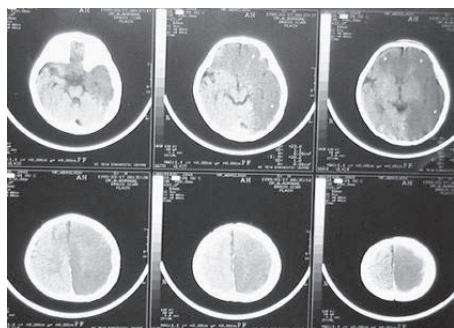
Axial CT shows extensive hypodensity involving the grey white matter of the left fronto parietal and temporo occipital region.
